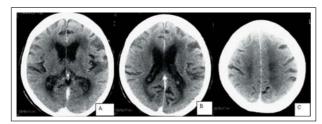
Axial CT at 3 levels of cranium used for evaluation of white matter scale: *A* and *B* for anterior, *B* and *C* for posterior score
